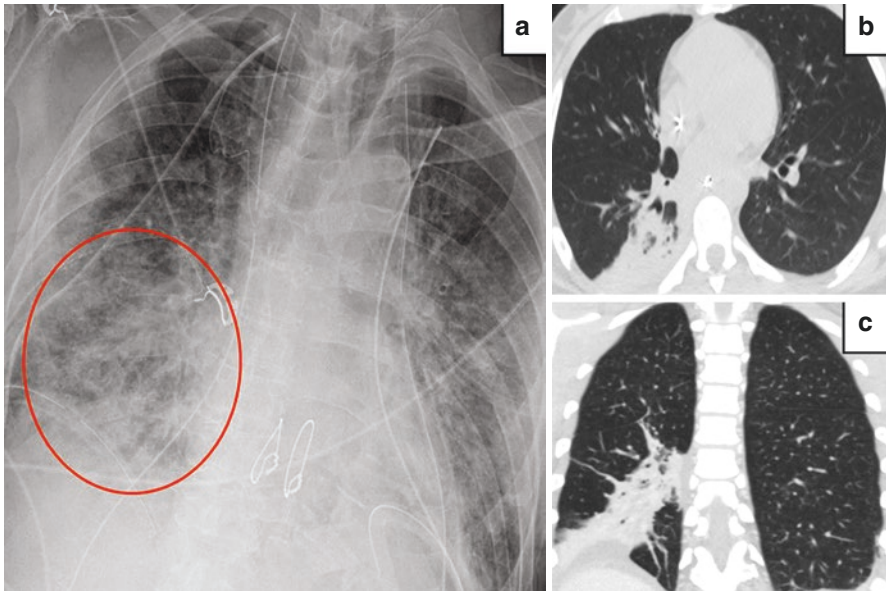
68 year old man post-operative day 2 after double lung transplantation for interstitial lung disease, with persistently high oxygen requirement and copious respiratory secretions after extubation. (a) Anterior-posterior chest radiograph of the transplant recipient reveals a focal consolidation in the right lower lobe (circled). (b) Axial and (c) coronal images from the donor's chest computed tomography scan 1 day after declaration of brain death following a drug overdose (2 days prior to organ procurement), revealing a focal consolidation in the right lower lobe which corresponded to the recipient's post-operative radiograph. Directed bronchoalveolar lavage (BAL) from the recipient and pre-donation BAL from the donor both revealed *Escherichia coli*
